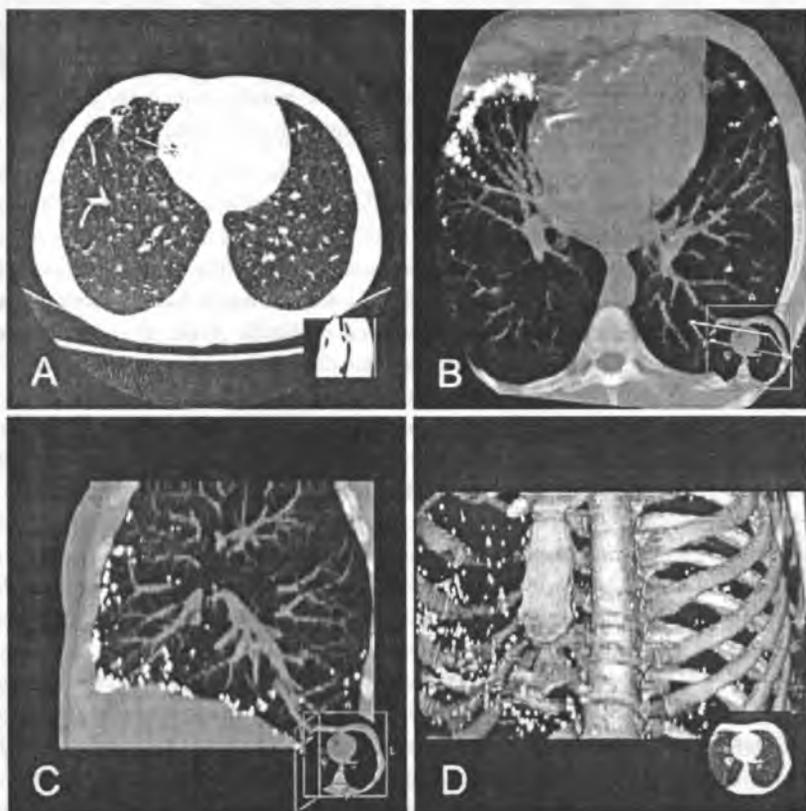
Computed tomography of the chest; A) HRCT, axial projection – the grains of mercury localized in the parenchyma of the lungs and in the heart. Areas of ground glass density as the signs of slight overhydration; B) MIP reconstruction, oblique projection – High concentration of the mercuric deposits in the middle lobe and in myocardium; C) MIP reconstruction, sagittal projection – subpleural deposits; D) VR reconstruction – distribution of the mercuric particles in the chest
